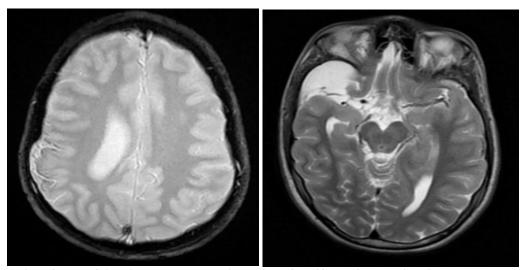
Axial T2 and T2 * weighted MRI showing voids of gyriform signals with right cerebral hemiatrophy and a right temporal arachnoid cyst
